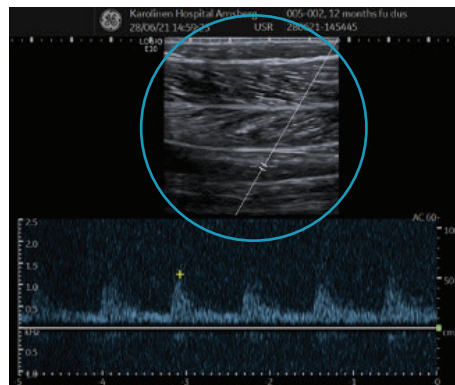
Duplex ultrasound
